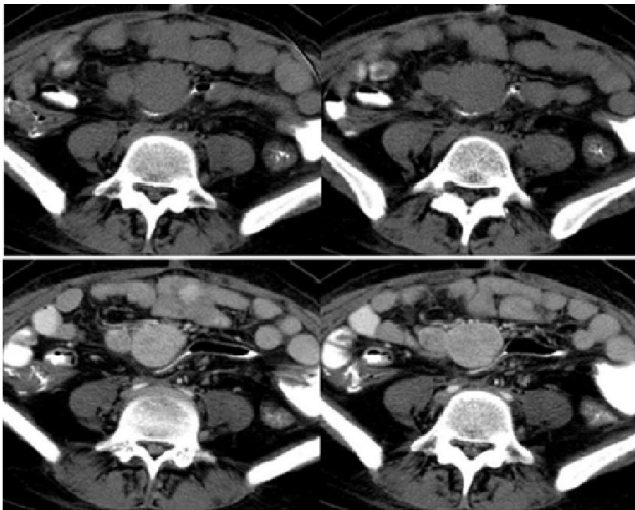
axial CT scan of the lower abdomen (precontrast above and post contrast below) showing a hypervascular mesentric mass.
